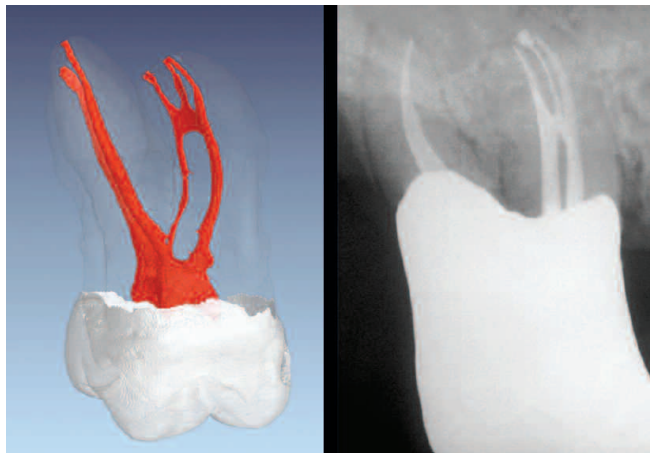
This μ CT image reveals a third system originating off the anastomosis between the MB1 and MB2 canals (Courtesy of Dr. Frank Paqué; Zurich, Switzerland). My 25-year recall of the buccal roots of tooth #3 depicts similar MB root anatomy and the longterm outcome of interdisciplinary treatment.
